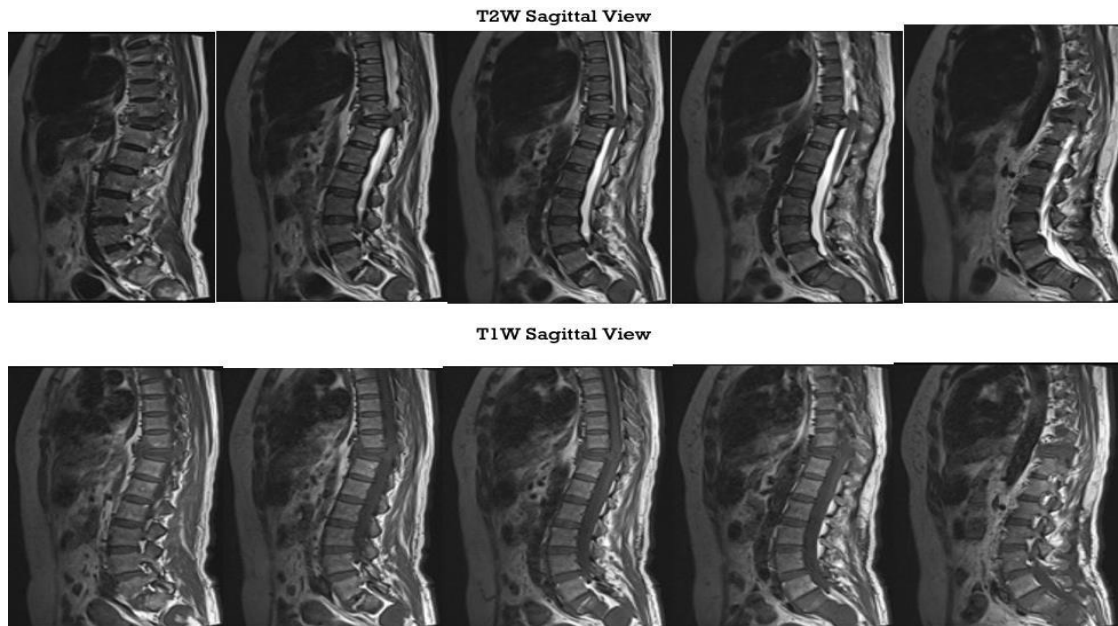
Magnetic resonance imaging of thoracolumbal.
